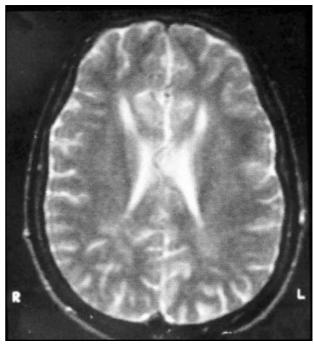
Axial MRI of head, T2-weighted image, showing a dysgenesis of corpus callosum, mainly in the anterior limb (Patient 2).
